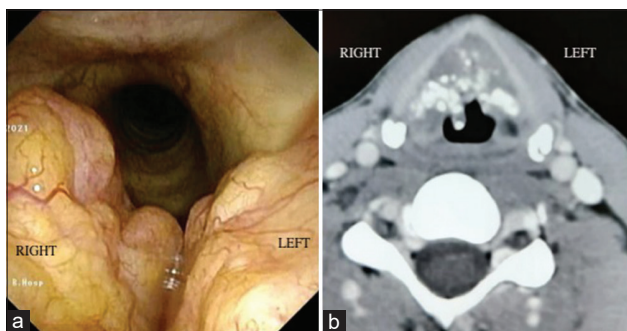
(a) Laryngoscopy picture of patient B, revealing bilateral bulky false vocal folds, hampering visualization of the true vocal folds. (b) HRCT image of patient B, showing extensive dystrophic calcifications within the bulky false vocal folds with no destruction of the thyroid cartilage
